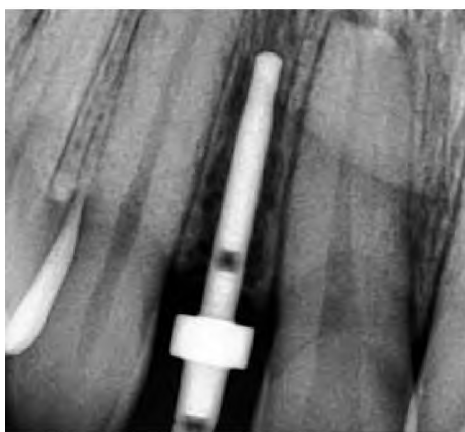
Intraoperative dental X-rays made to check the parallel positioning of the implants. In the areas of 1.2 and 2.2 teeth, two implants of 3.6 diameter and 10 mm length were installed.
